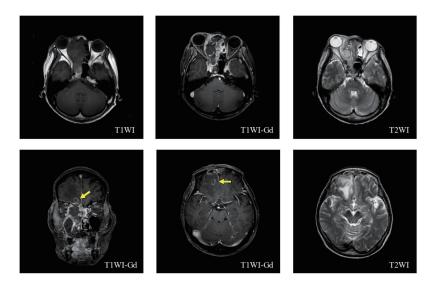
Axial T1-weighted and Gd-enhanced magnetic resonance images show a well-circumscribed, low-signal-intensity mass situated in the right frontal, ethmoid, and sphenoid sinuses. Coronal T2-weighted magnetic resonance images show a low- to high signal-density mass extending from the right frontal, ethmoid, and sphenoid sinuses to the intracranial frontal lobe.
